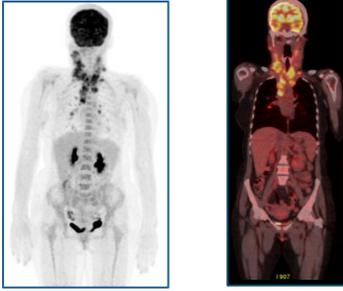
Positive PET/CT with multiple cervicomedial lesions that concentrate $[^{18}\text{F}]$ FDG
